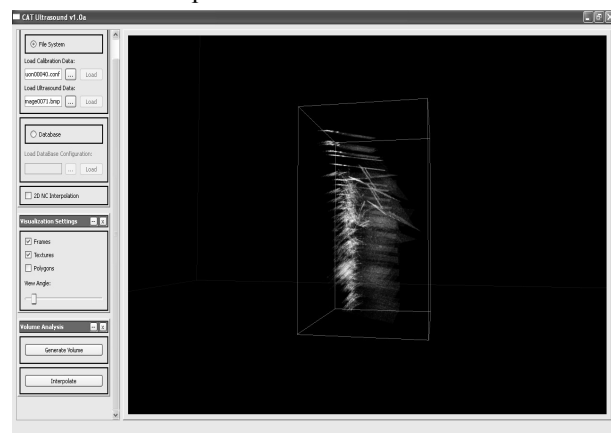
3D modeling of bones using B-Mode ultrasound.
